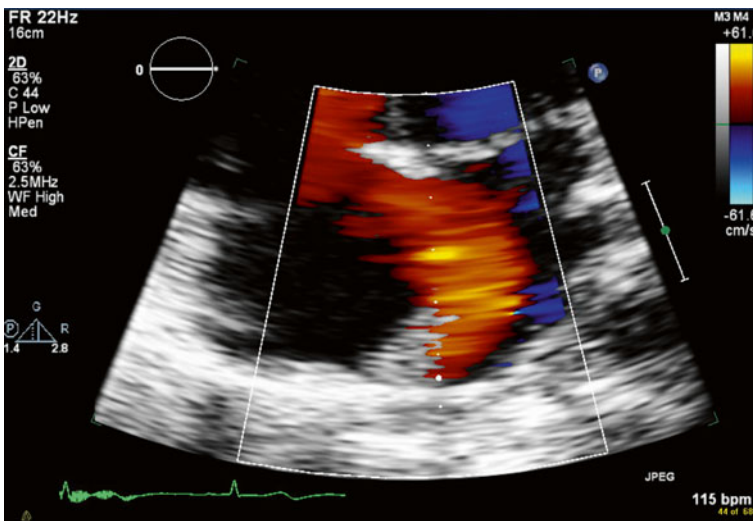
Left to right flow on Doppler echocardiogram
